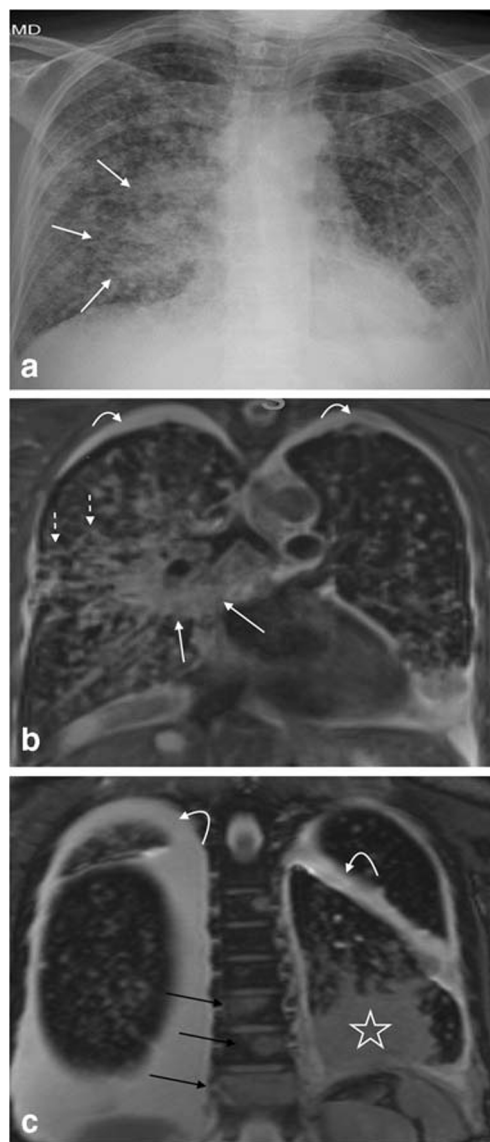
New diagnosis of stage IV right hilar small cell lung cancer with lymphangitic spread and metastases. a Frontal chest radiograph shows a mass in the right hilar and infrahilar regions (white arrow). Further characterization with b, c coronal steady-state free precision images demonstrates a hyperintense right hilar mass contiguous with subcarinal lymphadenopathy (white arrows) which encases the bronchovascular structures in the hilum. There is lymphangitic spread as evidenced by nodular thickening of the peribronchovascular interstitium (white dashed arrows). Bilateral pleural effusions (curved arrows) and osseous axial osseous metastases (black arrows) were readily identified. Incidentally noted is compressive atelectasis of left lower lobe (star)
